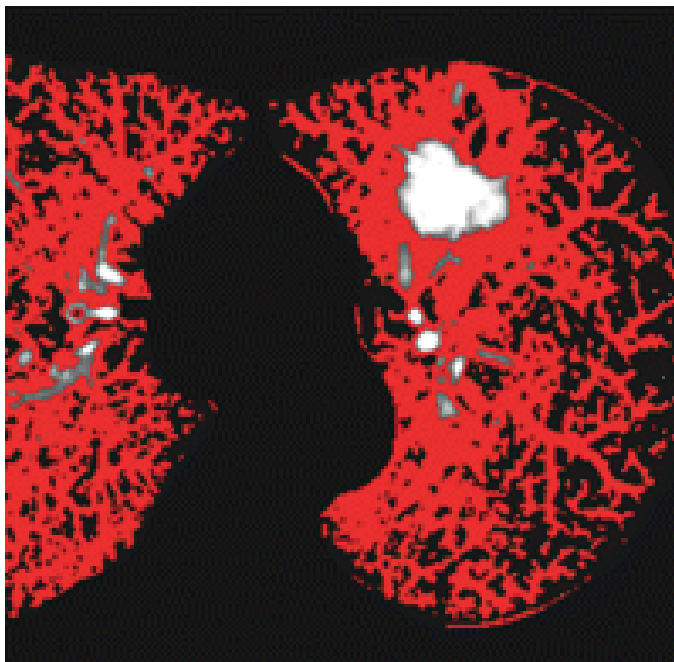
Quantitative CT scan shows functional lung (*red*), pulmonary emphysema (*black*), and lung cancer (*white*). (Ohno et al., 2007).
